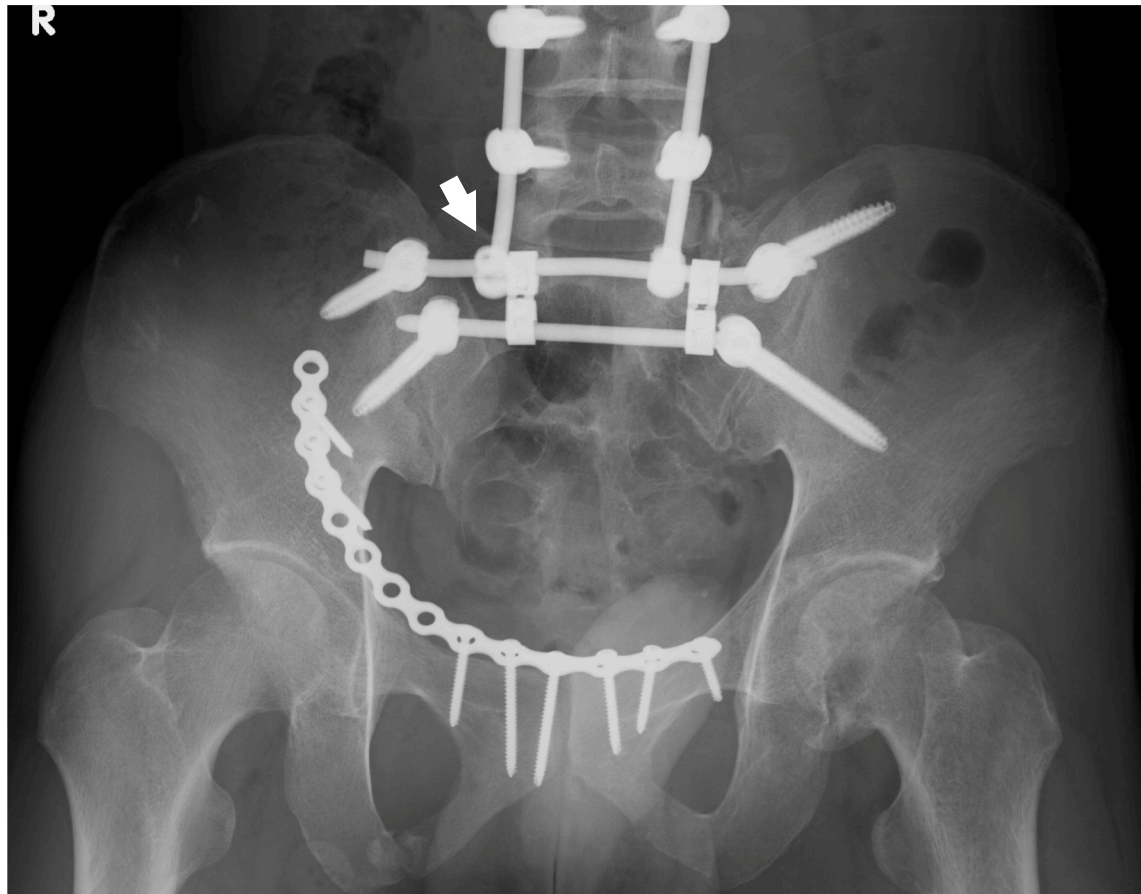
Anteroposterior X-ray. These show loosened ‘set-screw’ (white arrows) lying outside the screw head.
